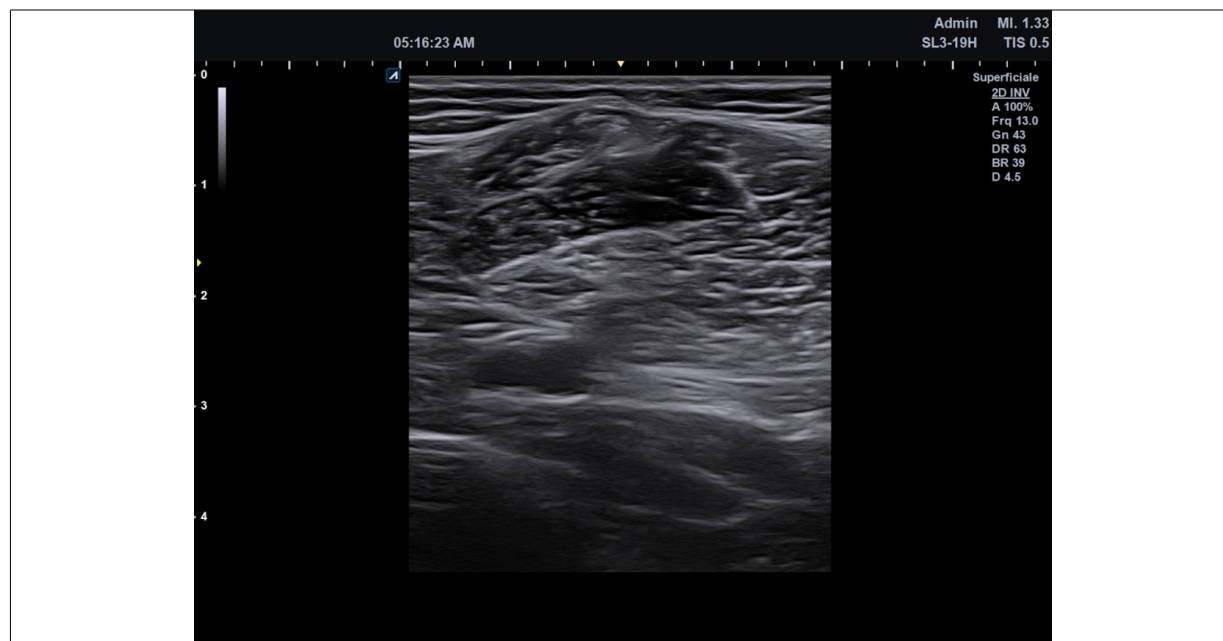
Ultrasound transverse view of distal hamstrings.
